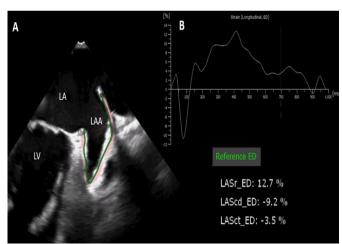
Left atrial appendage (LAA) strain analysis using speckle-tracking echocardiography (STE). (A) Mid-esophageal transesophageal echocardiographic (TEE) view at 90°, showing automated speckle-tracking of the LAA myocardium with manual contour adjustments. (B) Corresponding strain curve analysis displaying LAA reservoir strain (LAA-Sr), conduit strain (LAA-Scd), and contraction strain (LAA-Sct).
